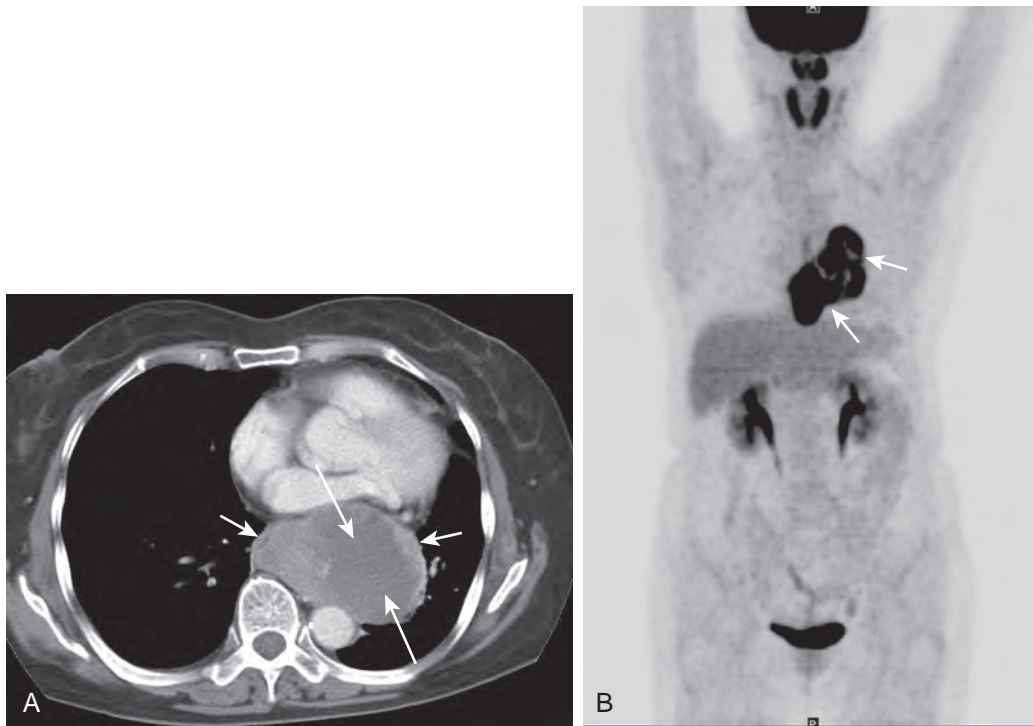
Esophageal GIST. A. Contrast-enhanced axial CT scan shows a large, heterogeneous, well-circumscribed mass that is inseparable from the left lateral wall of the distal esophagus. Note peripheral enhancing solid components (short arrows) and large internal cystic areas (long arrows). B. Coronal PET/CT scan (maximum intensity projection) shows uniform and marked FDG avidity of large left paraesophageal mass (arrows). The findings on CT and PET enable differentiation of GISTs from leiomyomas. (From Winant A, Gollub MJ, Shia J, et al: *Imaging and clinicopathologic features of esophageal gastrointestinal stromal tumors*. *AJR* 203:306–314, 2014.)
